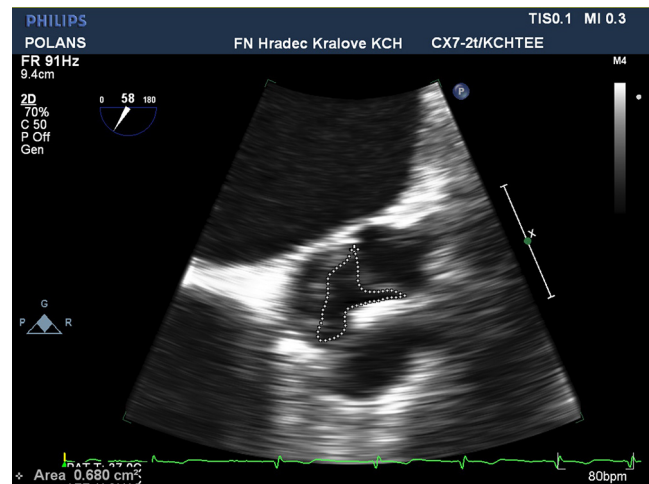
Aortic valve orifice planimetry, calcifications of leaflets and annulus – transesophageal echocardiography.
